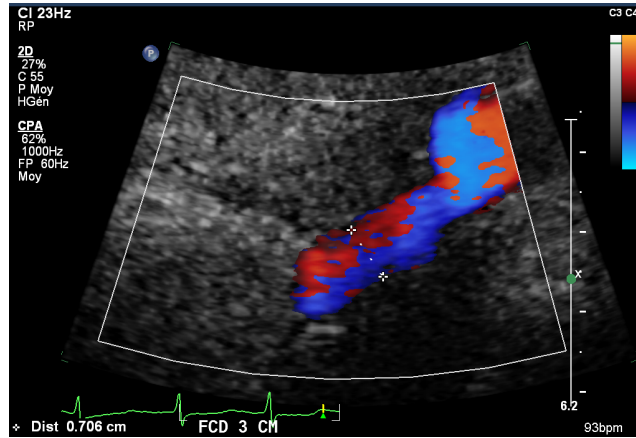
B-mode Doppler ultrasound image of the common femoral artery. Diameter is measured manually during diastole. Red and blue areas indicate the zones where flow moves towards and away from the transducer.
